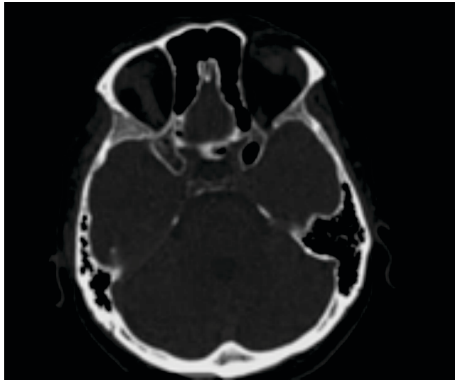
CT Scan Report Showing the ACP
